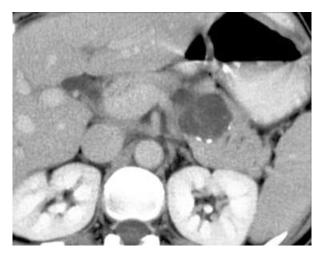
Contrast-enhanced CT scan of the abdomen reveals a hypodense well-circumscribed lesion in the body of the pancreas. Internal septations are seen as are calcifications in the wall-suggestive of a mucinous cystic neoplasm.
